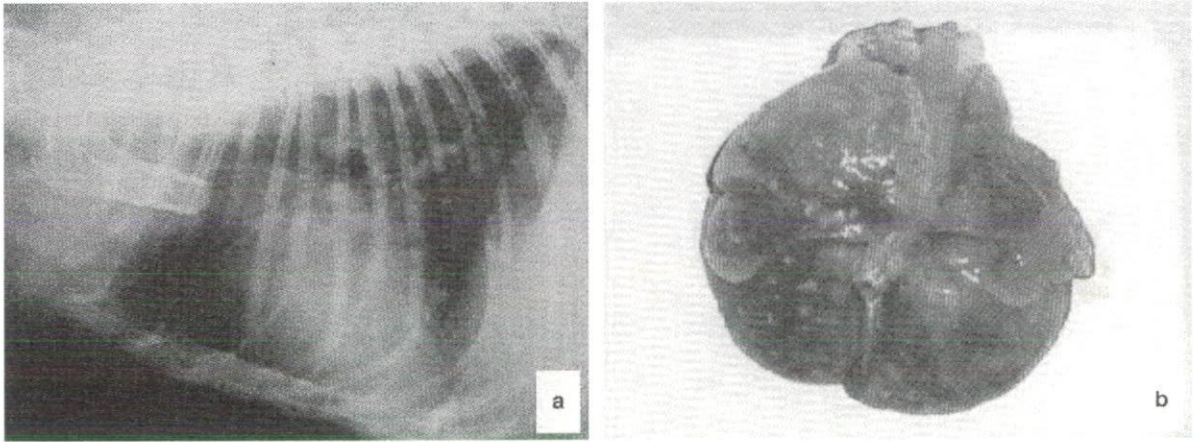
A chest x-ray showed multiple foci 3 days before death (a), and abundant rice-sized nodules in the lungs found upon postmortem examination (b) in Case 2.
